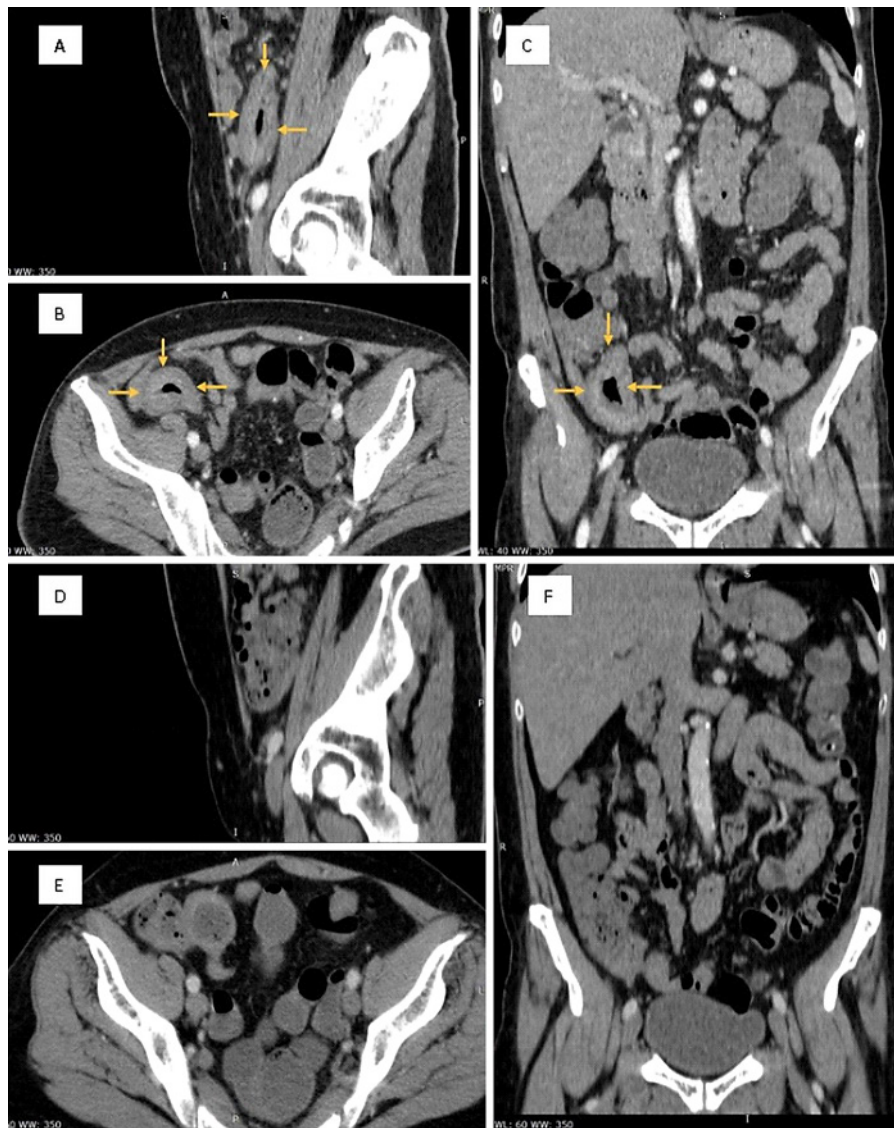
Abdominal CT after the sixth cycle of CHOP chemotherapy in sagittal (A), axial (B), and coronal view (C). Terminal ileum thickening was still present with marked shrinkage (arrows). After chemotherapy abdominal CT scan showed absence of terminal ileum thickening in sagittal (D), axial (E), and coronal view (F).
